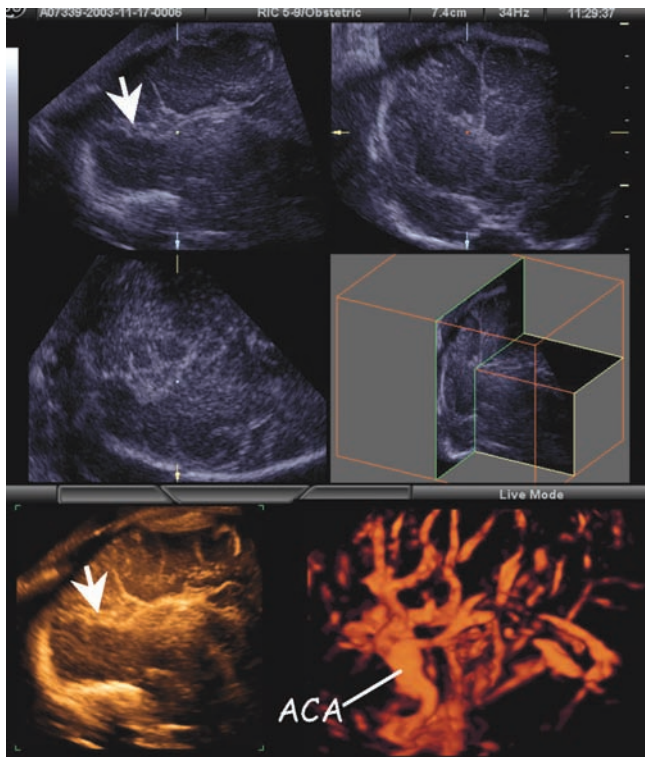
Agnesis of the corpus callosum with abnormal gyration at 36 weeks of gestation. Upper figure shows the three orthogonal view of the brain with agnesis of the corpus callosum with an abnormal gyrus (arrow). Lower left figure is a thick slice of the sagittal section. Abnormal gyration (arrow) is more clearly demonstrated. Lower right shows the intracranial angiostructure by 3D power Doppler. Normal pericallosal artery does not exist and radial formation of the branches of anterior cerebral arteries (ACA) is seen.
